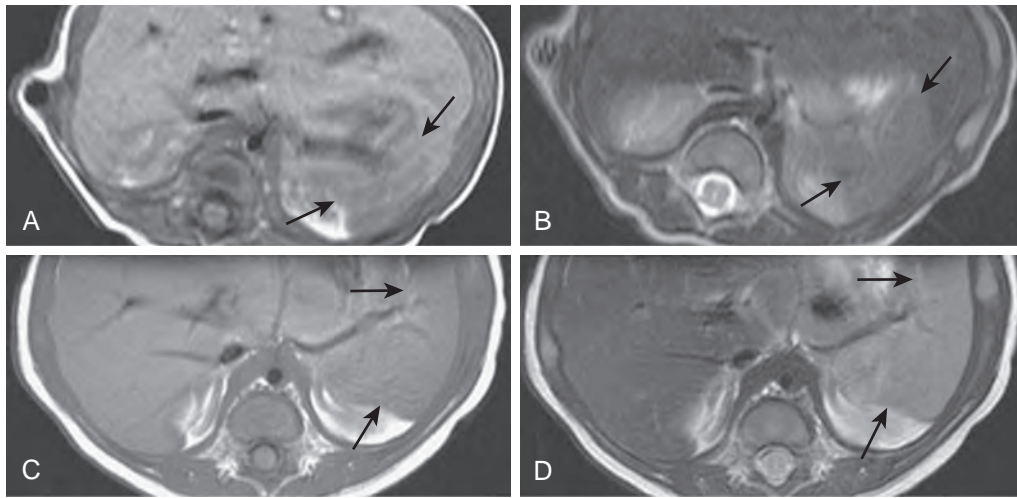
Normal spleen: MR findings. MRI demonstrates the normal change in signal intensity of the spleen (arrows) relative to the liver in a 9-day-old neonate (A and B) and in the same child at 12 weeks (C and D). In the T1-weighted image (A) and fast spin-echo T2-weighted image (B) of the 9-day-old infant, the neonatal spleen has relatively lower signal intensity, particularly on T2-weighted sequences, because of the higher ratio of vascular red pulp to white pulp. The T1-weighted image (C) demonstrates MR findings for the same child at age 12 weeks. As the lymphoid tissue of the white pulp matures, the spleen (arrows) becomes moderately hyperintense to the liver on fast spin-echo T2-weighted images (D).
